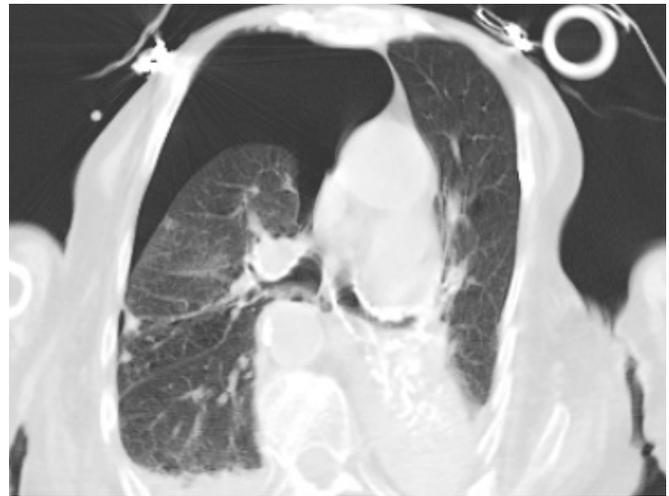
Large area of pneumothorax was seen at CT.
